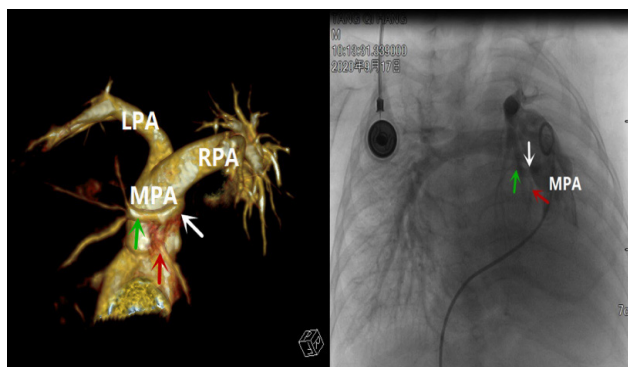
CTA and cardiac catheterization conforming the RCA (red arrow) and LCA (green arrow) with a common trunk (white arrow) originated from the main pulmonary artery (MPA)
